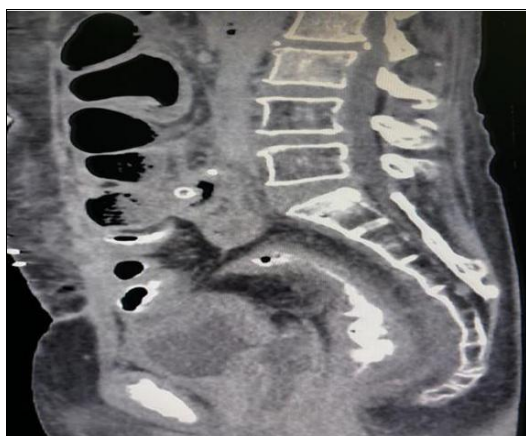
Sagittal CT scan showing pelvis
